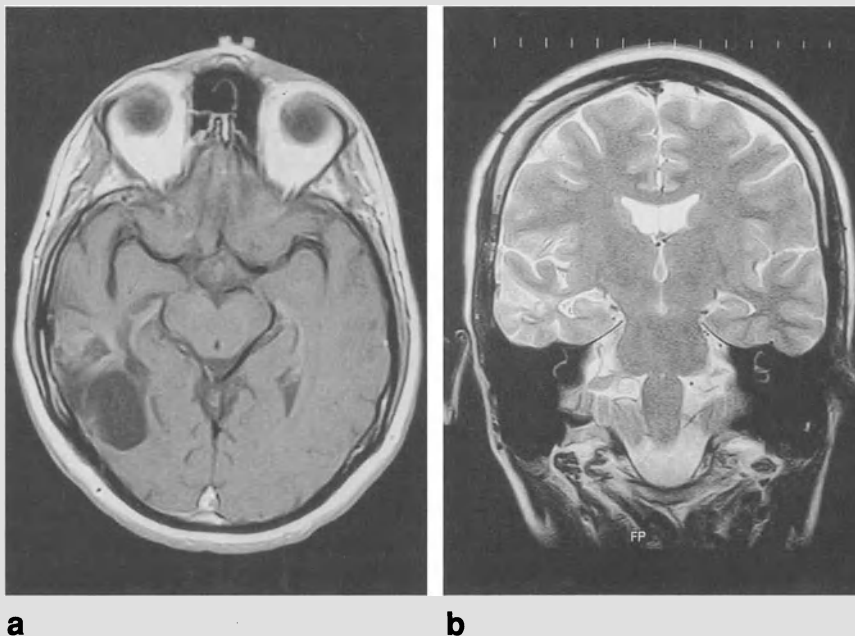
(a) Axial MRI after lesionectomy of a grade II temporal astrocytoma. The patient showed persistence of partial complex seizures after surgery. (b) Coronal T2 weighted MRI of the same patient shows left hippocampal atrophy in association with the surgically treated temporal lesion. The patient underwent as 2nd step surgery temporal lobectomy and amygdalo-hippocampectomy which allowed complete control of epilepsy
